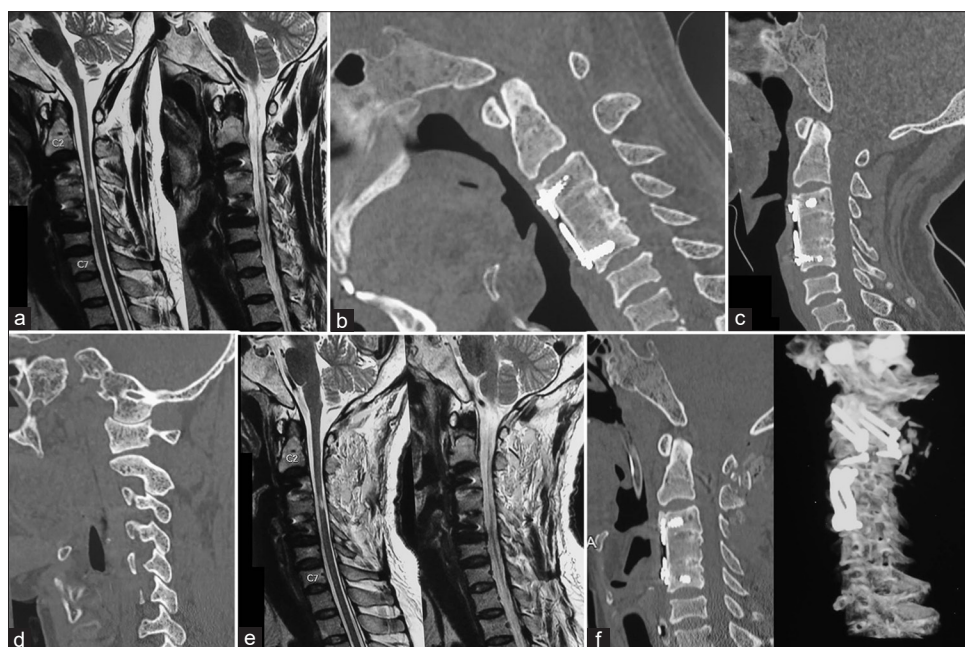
Images of a 34-year-old male patient. The patient had been operated 6 years before presentation. A C3–C4 and C4–C5 discectomy with anterior plating had been successfully performed. (a) T2-weighted magnetic resonance imaging showing the anterior fixation from C3 to C5 level. There is no evidence of compression at C1–C2 or C2–C3 levels. (b) Computed tomography scan with the head in flexion showing C3–C4 and C5 fusion and anterior plate. There is no evidence of C1–C2 or C2–C3 instability. (c) Computed tomography scan with the head in extension. The odontoid process shows minimal realignment when compared to the image on flexion. (d) Sagittal cut of computed tomography through the facets showing Type 3 atlantoaxial facet instability. (e) Postoperative T2-weighted magnetic resonance imaging. (f) Reconstruction of computed tomography scan image showing atlantoaxial and C2–C3 fixation implants
